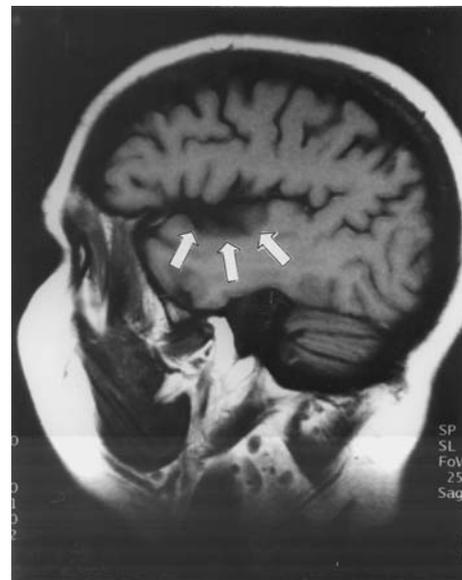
A lateral T1 magnetic resonance image showing involvement along the Sylvian fissure in the left cortex. This view shows the compromise of key auditory regions of the superior temporal plane.
